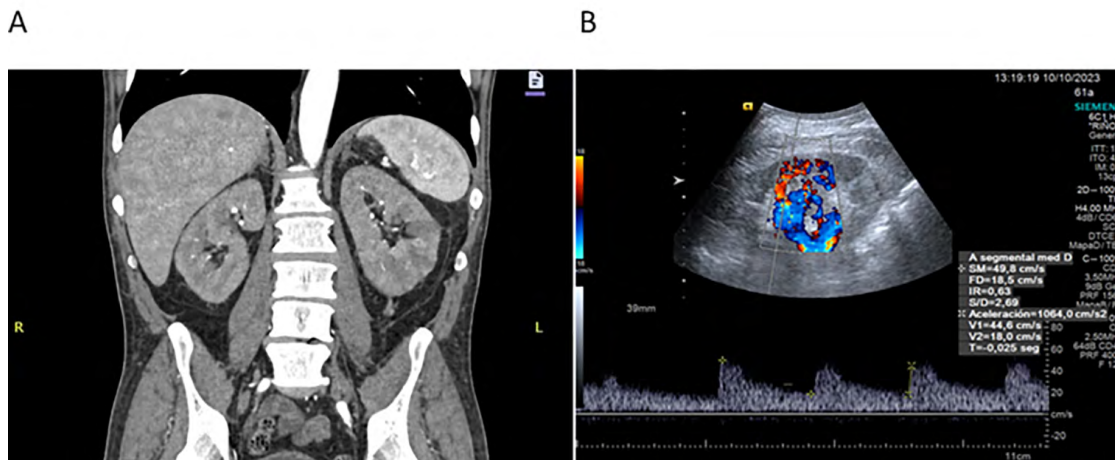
A. Contrast-Enhanced CT-SCAN revealed multiple triangular subcapsular hypodense areas consistent with renal infarcts. B: Renal ultrasound with doppler after 2 months of treatment.
